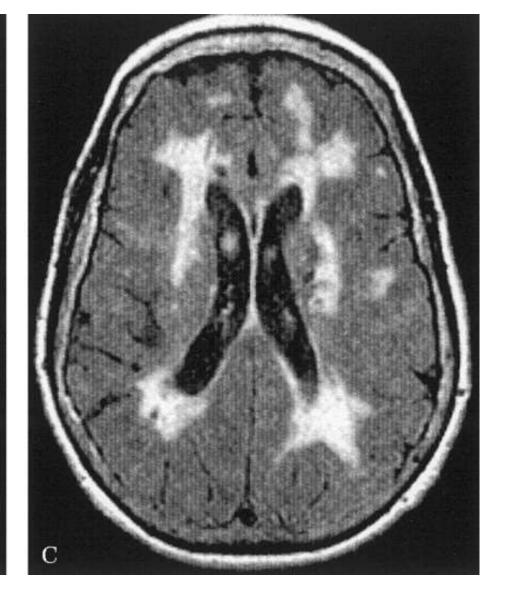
MRI findings associated with CADASIL. First slide shows anterior temporal leukoencephalopathy. Second arrow shows the diffuse periventricular white matter lesions
